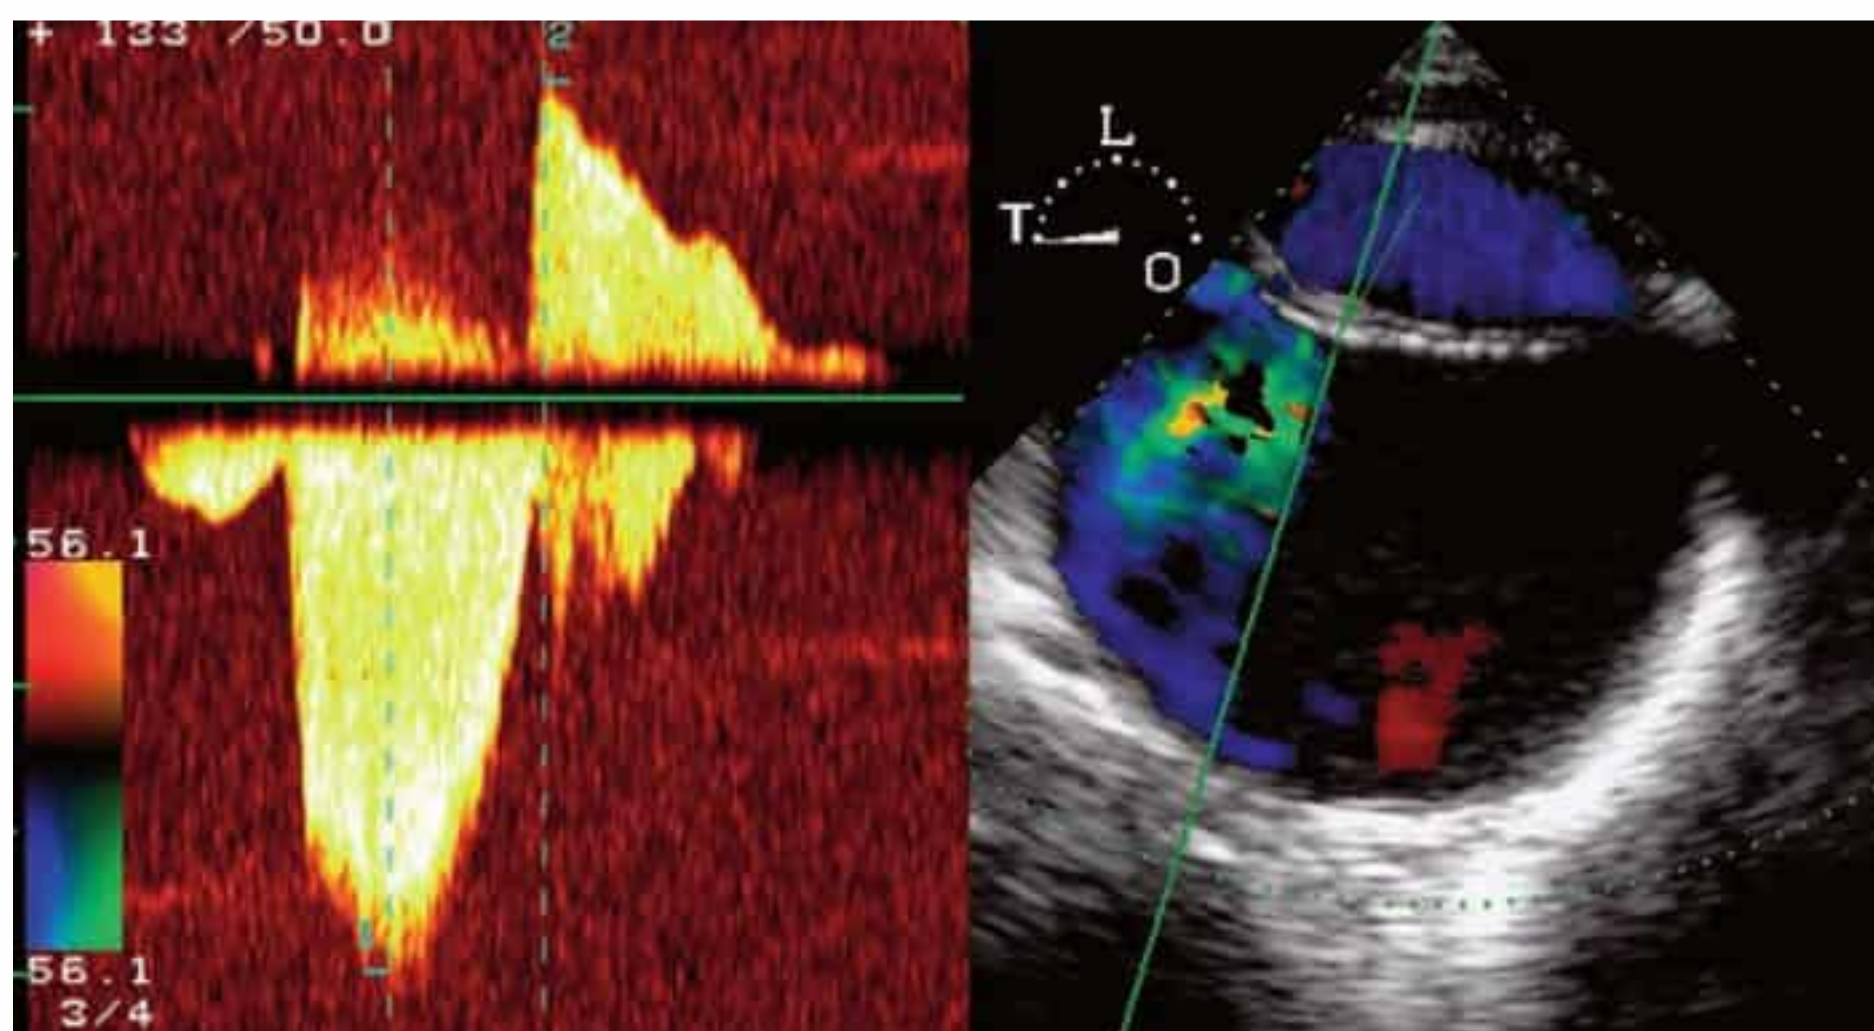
Transesophageal CW Doppler echocardiography for characterizing flow across the entry during systole and diastole. The Doppler spectrum shows that flow is directed from the true to the false lumen during systole and that flow reversal occurs during diastole.
